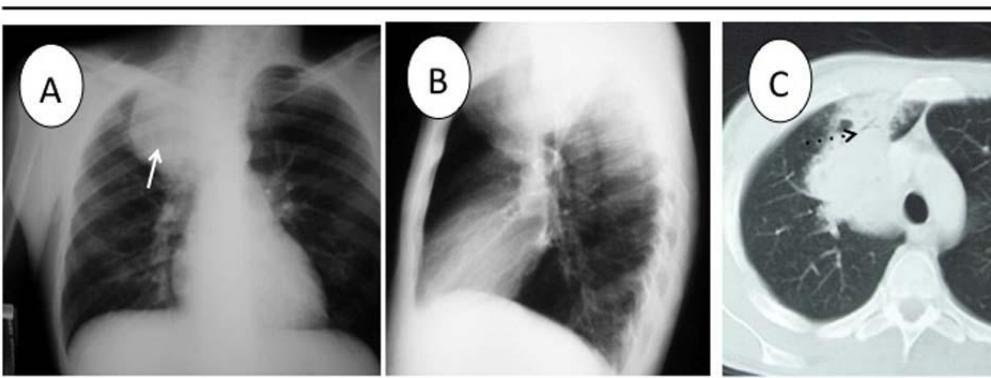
47 year old male, HIV positive, with fever and pneumonia symptoms. On the conventional chest study a lung mass was discovered (arrow). The CT showed air bronchogram within the lesion (dashed arrow). The final diagnosis was a *Rodococcus* motivated abscess.
